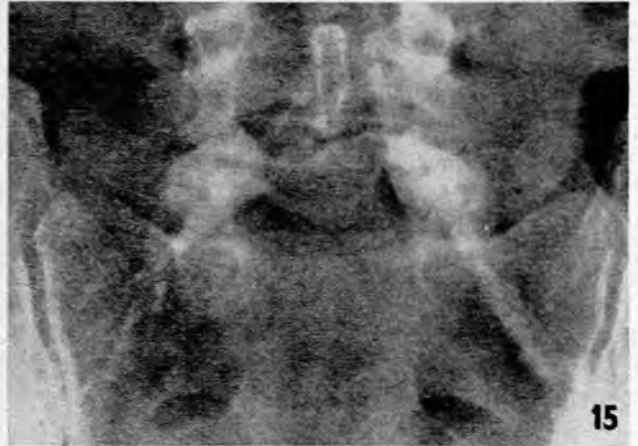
X-ray showing calcification of common iliac arteries.
